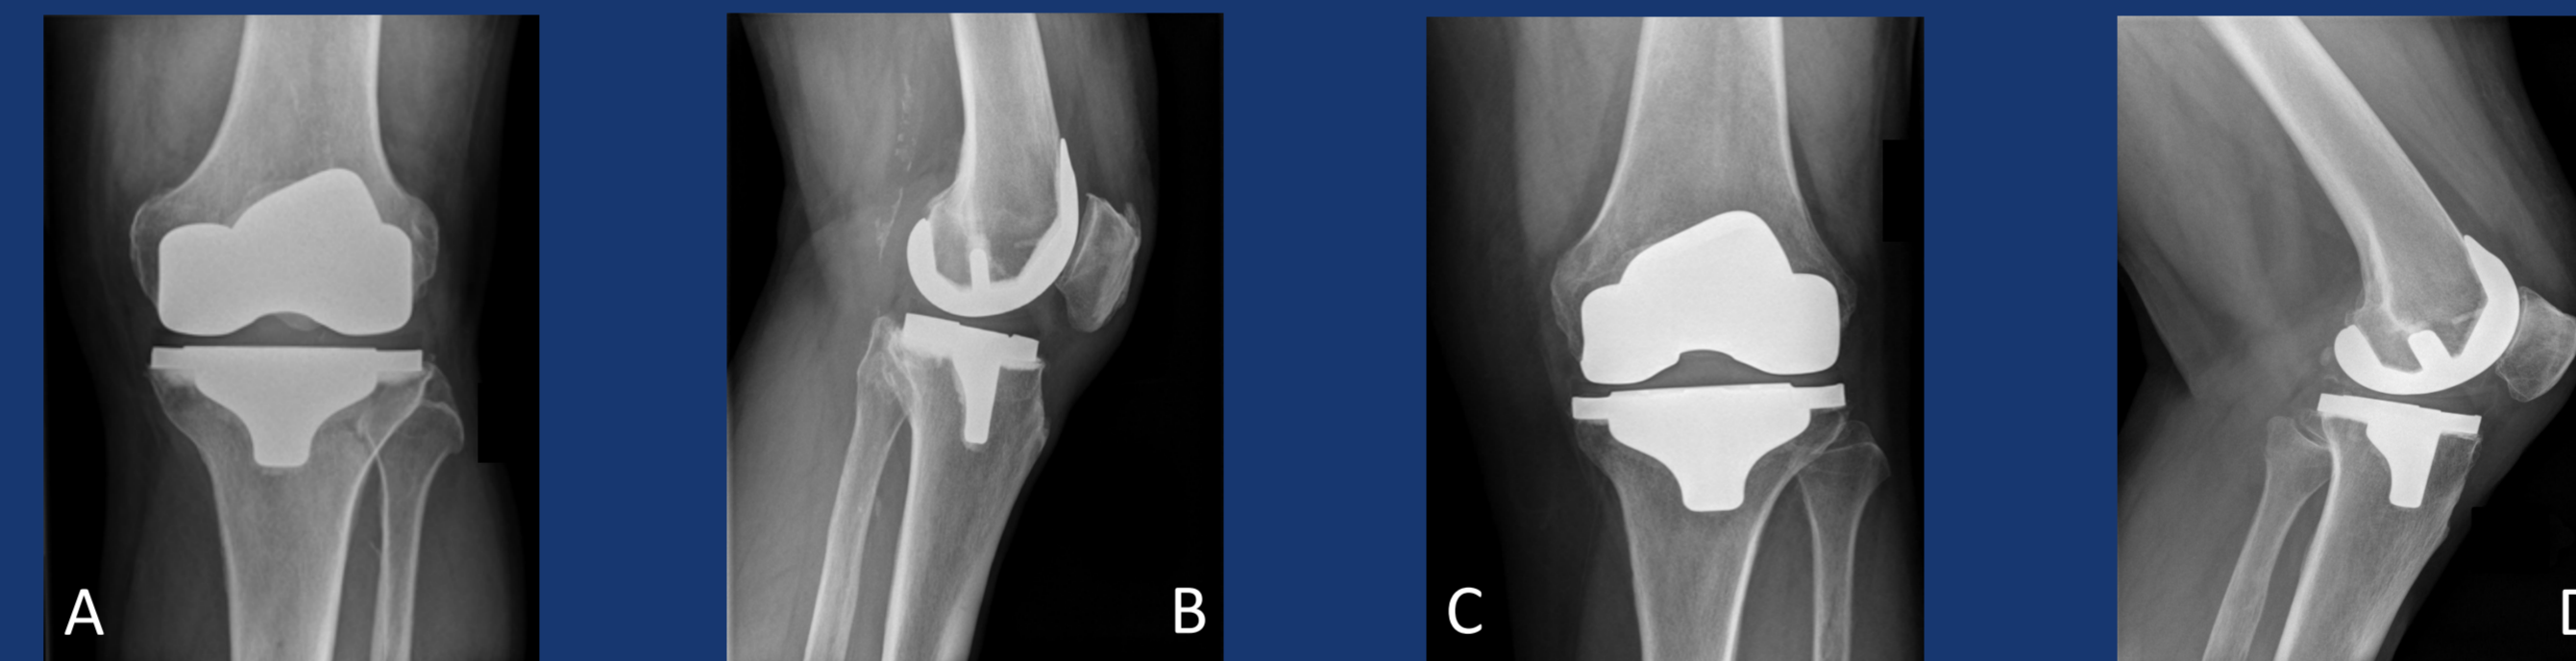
Radiographs of Mechanical versus Kinematic Alignment TKA
